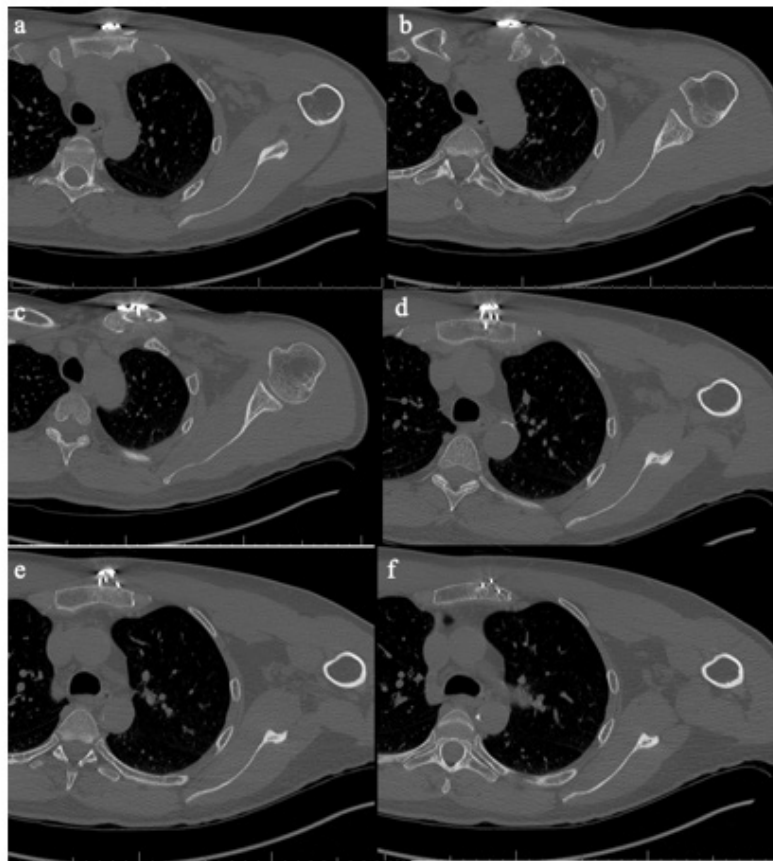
Cranial to caudal axial CT cuts (a-e) of the left clavicle two weeks post-operatively demonstrating anterior displacement of the medial plate off of the sternum.
